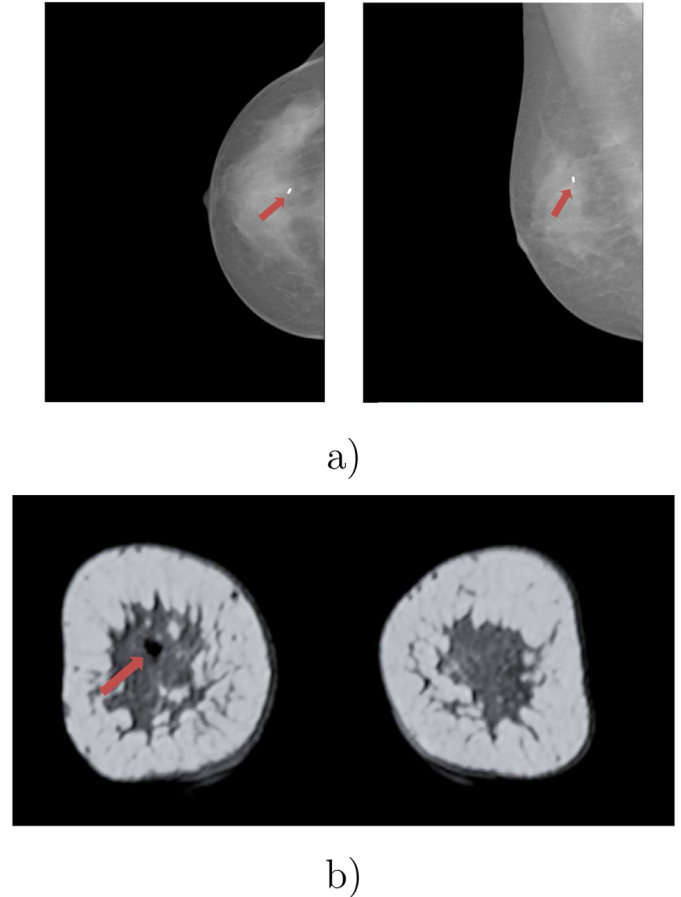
Metallic clip for image-guided biopsy. The clip is visible in (a) CC and MLO mammograms as a bright spot, while in (b) MRI it yields a magnetic susceptibility artifact, which is visually seen as a small black bubble. The landmark position is shown using a red arrow in the images. (For interpretation of the references to colour in this figure legend, the reader is referred to the web version of this article.)
